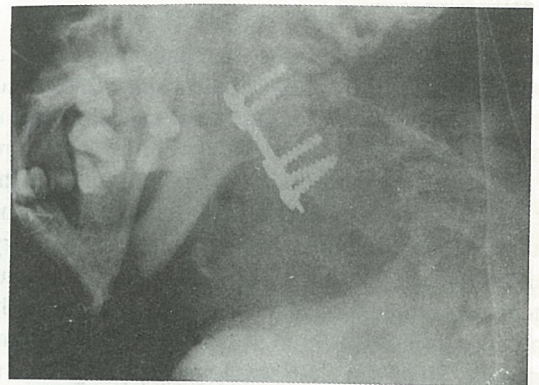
Postoperative lateral x-ray showing anterior plate with some correction of the deformity and wire stitches on the mandible.
